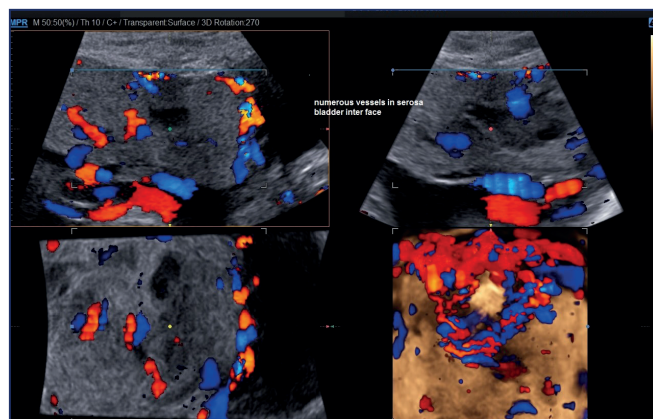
3D power Doppler showing abnormal placental lacunae, disruption of the uterine serosa-bladder interface, numerous vessels invading the uterine serosa-bladder interface.
